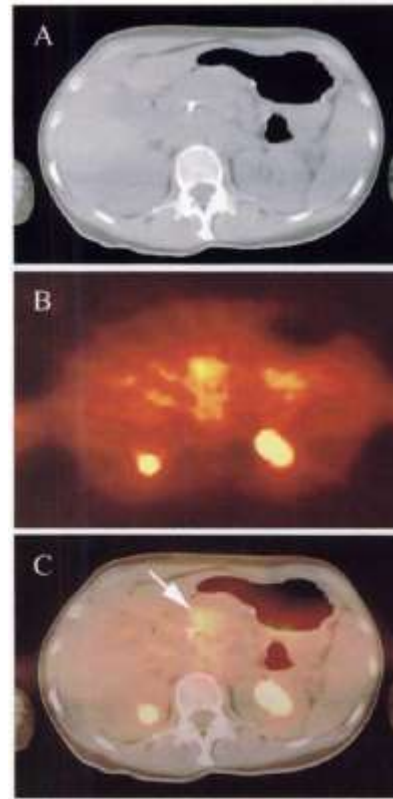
A 38-y-old woman with history of unresectable pancreatic cancer. Laparotomy revealed presence of liver metastases. (A) CT image. (B) Difficulty of accurately localizing FDG uptake can be seen from PET image. (C) Fused image enabled uptake to be localized to pancreas and not to transverse colon as had originally been thought.
